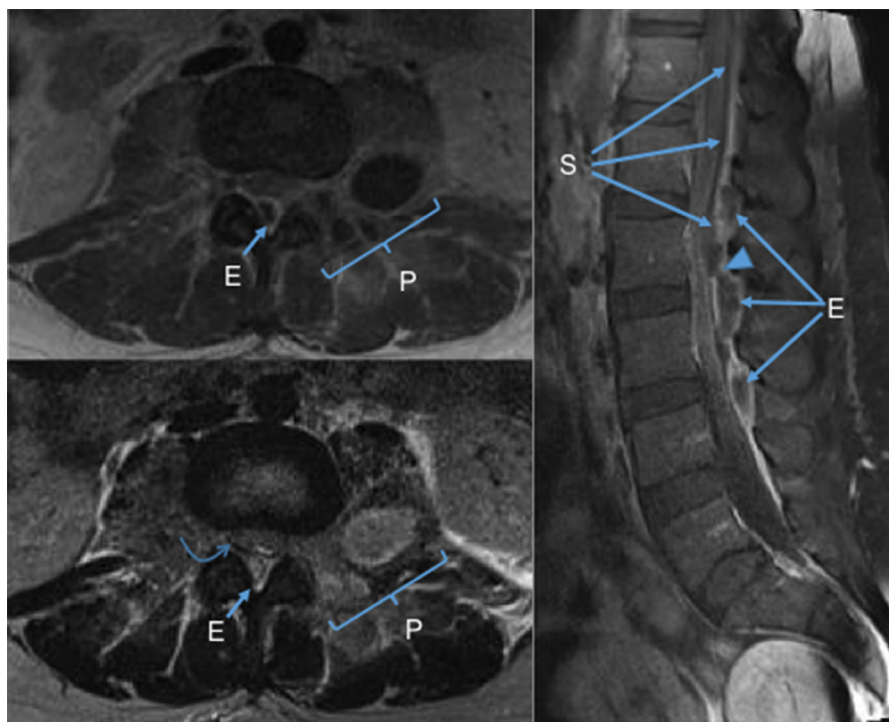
Preoperative magnetic resonance imaging (MRI) of the lumbar spine. (Top left) T1-weighted contrast enhanced axial imaging demonstrates the ring-enhancing epidural abscess (E) in the lumbar spine. (Bottom left) T2 axial shows a fluid collection noted external to the dura (curved arrow). (Right) Sagittal T1 with gadolinium imaging redemonstrates the epidural abscess and also the subdural abscess (S), which was confirmed on repeat imaging. The transition between epidural and subdural collections is depicted at the L2–L3 levels (arrowhead). A paraspinous abscess (P) was also present involving the left paraspinous musculature and left psoas muscle.
